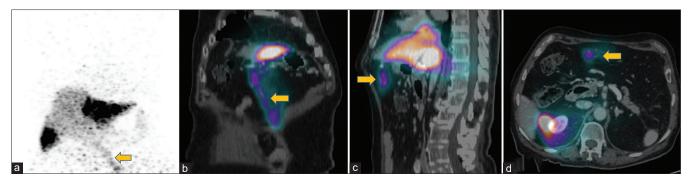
(a) Reconstructed single photon emission computed tomography (SPECT) in transaxial (d), sagittal (c) and coronal (b) views co-registered to corresponding contrast enhanced computed tomography (SPECT/CT) localizes the extrahepatic tracer uptake to the hepatic falciform artery (solid arrows)
